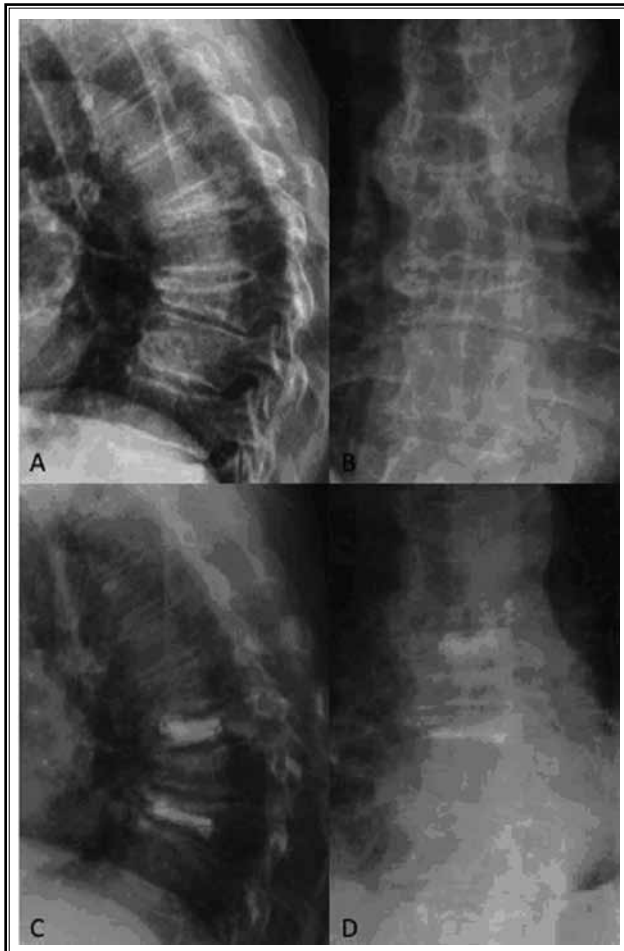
Preoperative (A, B) and postoperative (C, D) radiographs of a patient treated by the Kiva® Treatment System at vertebrae T7 and T9 (lateral view = A, C; anterior-posterior view = B, D)
